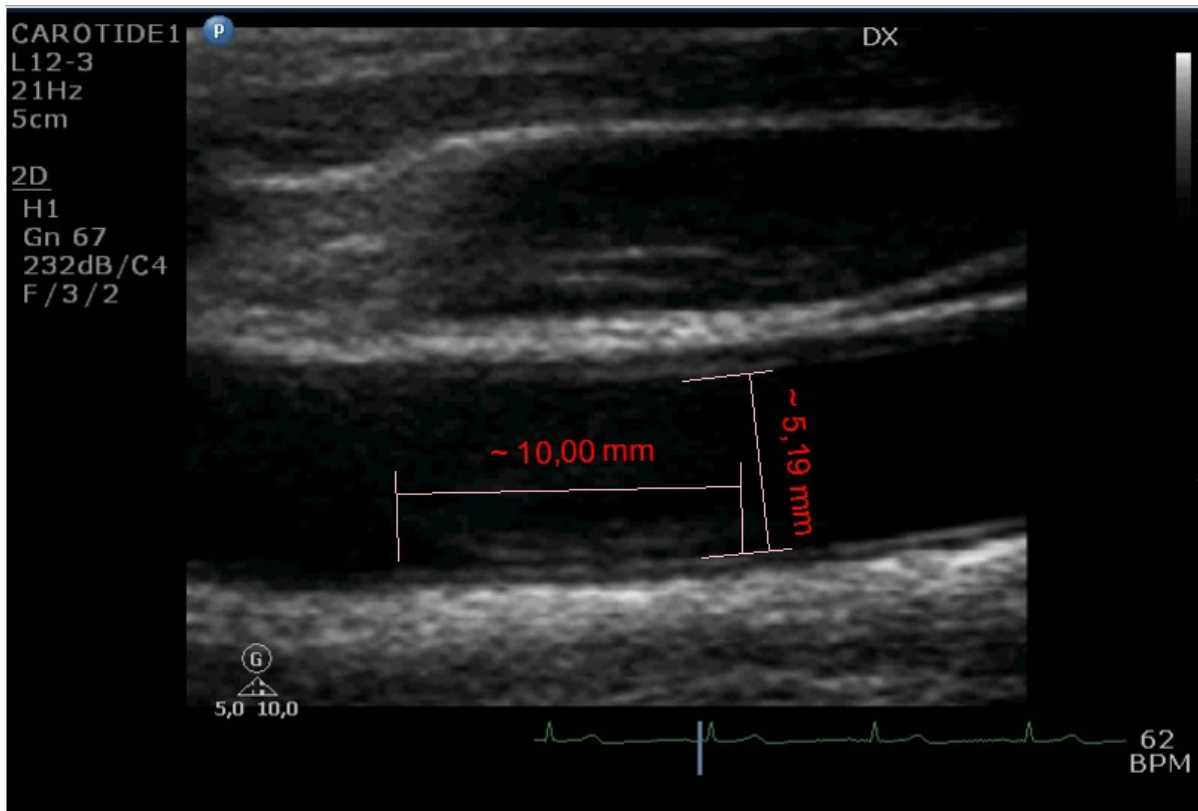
Ultrasound image showing the measurement of common carotid diameter.
